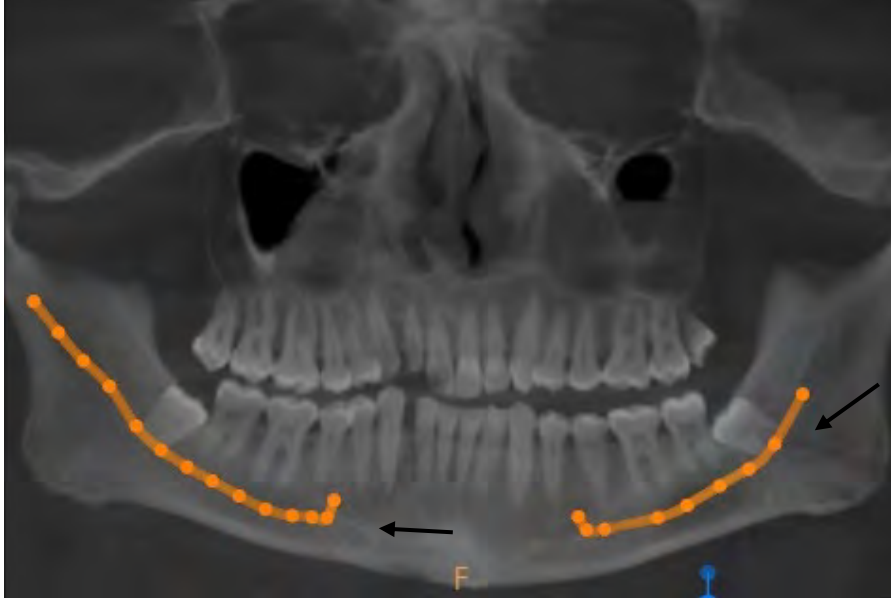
Preoperative CBCT
